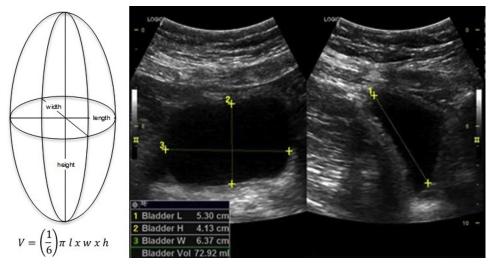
Prolate ellipsoid method of acquiring bladder volume via ultrasound.
